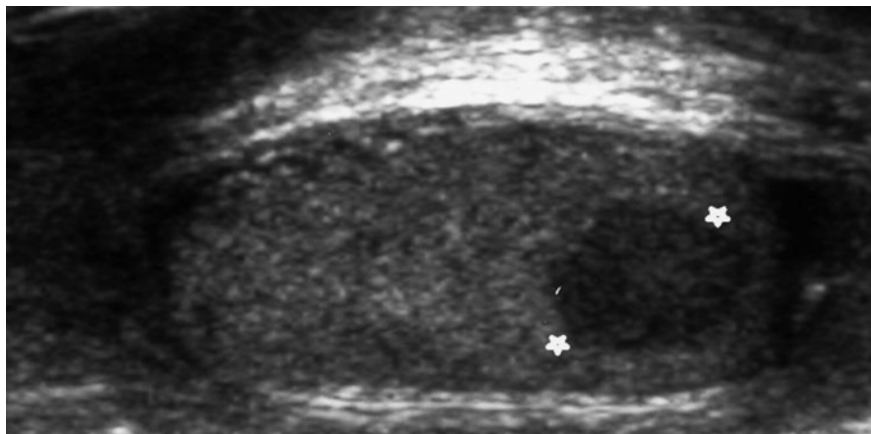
Ultrasonography showing an ovoid and hypoechoic 15×12 mm sized mass in the upper pole of left testis (white stars).
